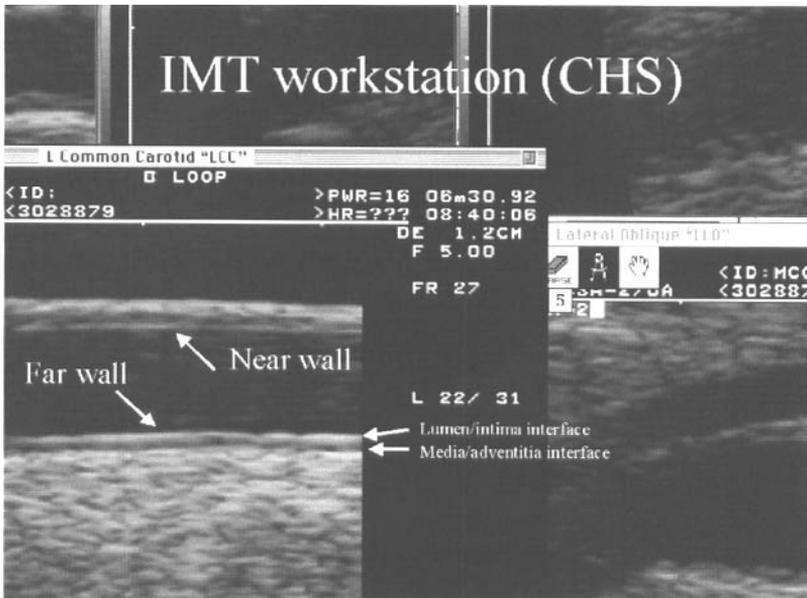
This image from a carotid ultrasound workstation shows an image with focus on the far wall of the common carotid artery. Wall thickness is measured as
